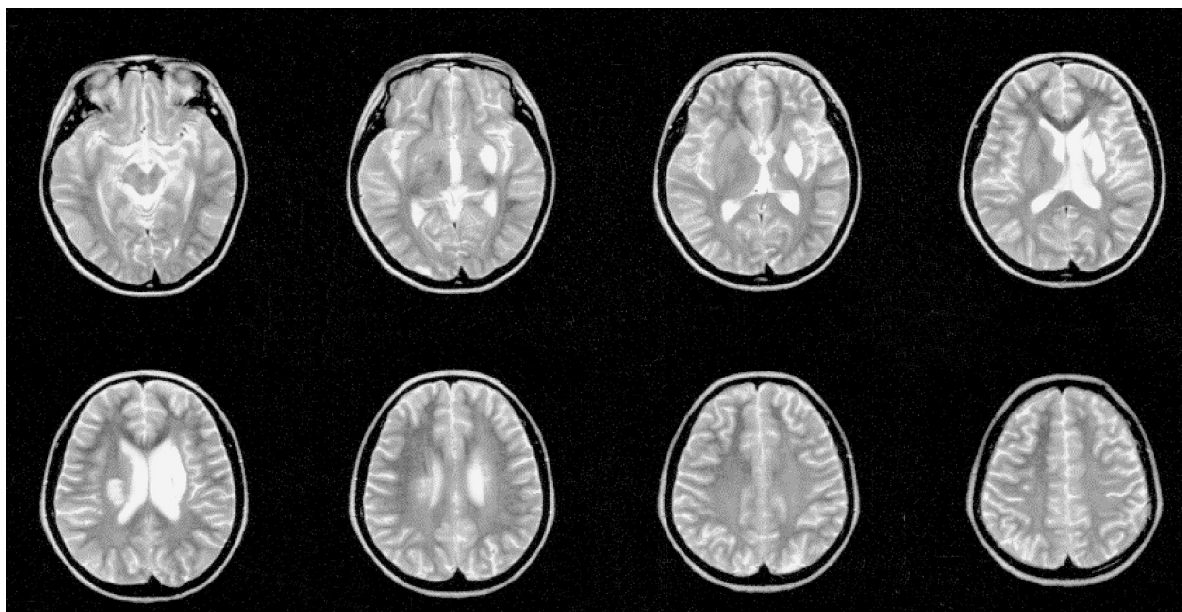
The MRI on admission showed fresh infarction beside the right ventricle, cerebromalacia in the left basal ganglia, and lacunar infarction in the right frontal subcortex.
